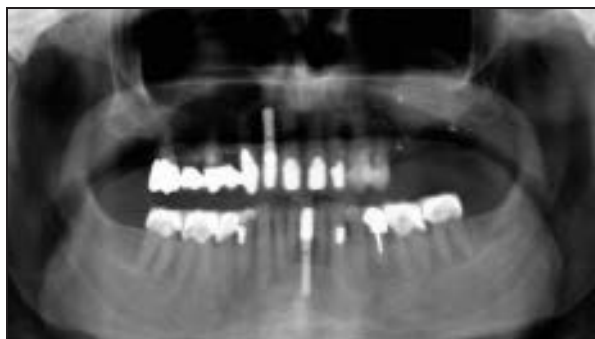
Panoramic radiograph of the patient 14 years after the grafting procedure.
